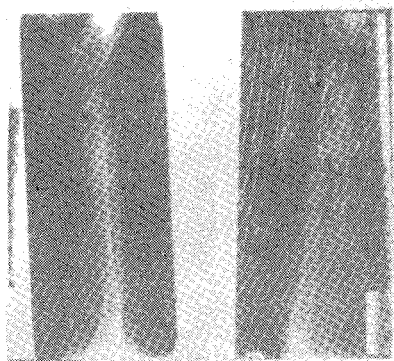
Radiograph of the right radius showing evidence of incorporation of the fibular graft
